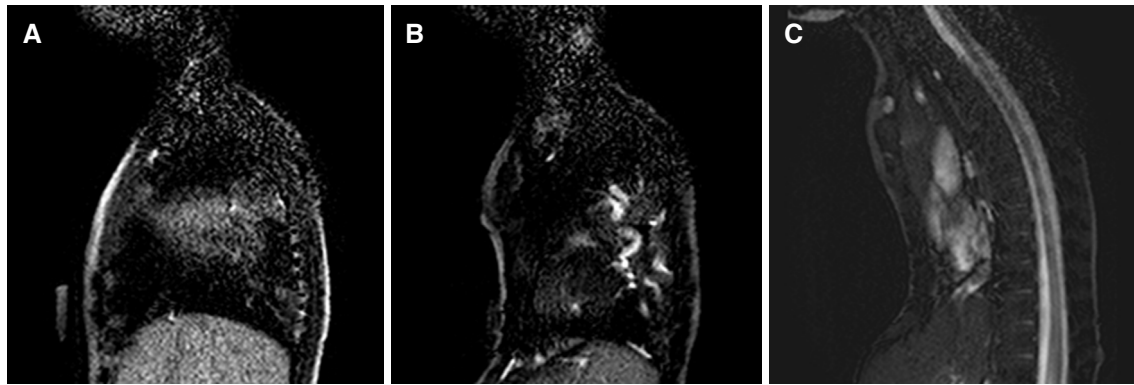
(A) A midline sagittal image from the dynamic magnetic resonance imaging in a patient with pectus carinatum chest is shown before the balloon brace is insufflated; (B) with sufficient insufflation of the balloon, the chest is made flat. This level of correction corresponds to the desired target of chest correction; (C) with extreme insufflation, the pectus carinatum chest can be converted to a pectus excavatum chest
